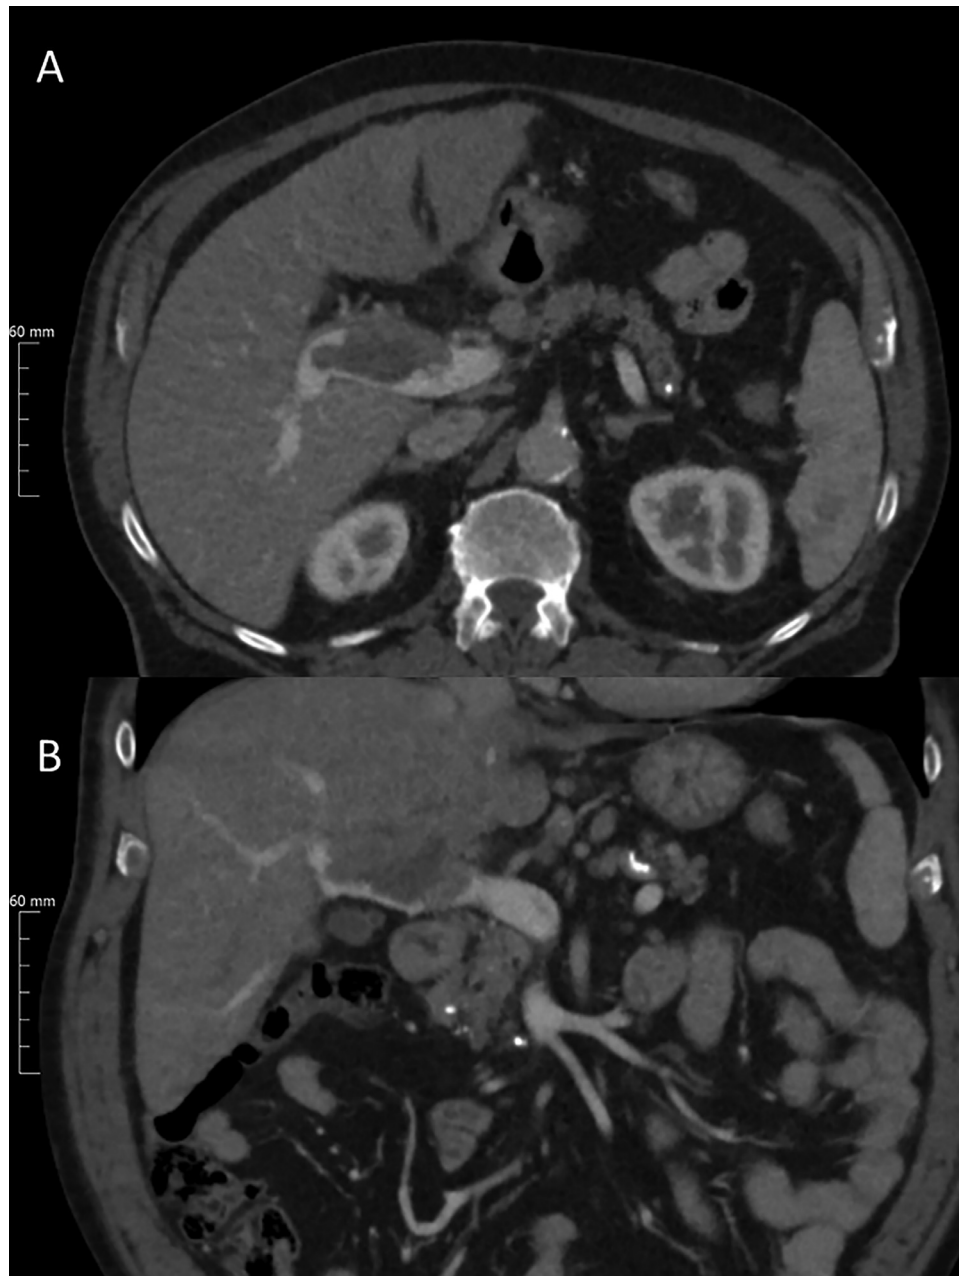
Incidental hepatocellular carcinoma (HCC) in a 72-year-old patient. Tumor thrombosis of the portal vein and altered tissue structure on CTA in axial (A) and coronal 4 mm reformation (B). Diagnosis of a diffusely growing primary liver tumor with portal vein thrombosis, subsequently confirmed upon biopsy.
